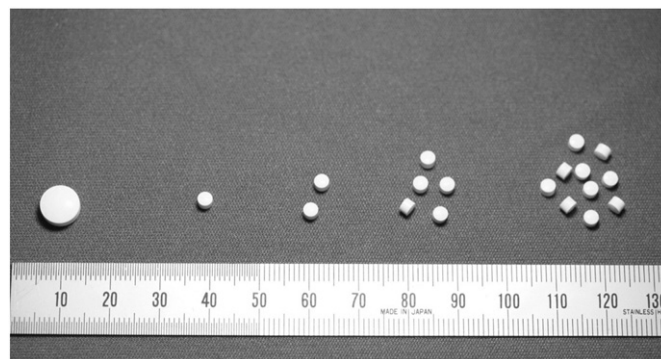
Conventional tablet and mini-tablet used in this study. The diameters of a conventional tablet (CT) and mini-tablet (MT) were 8.0 and 3.0 mm, respectively. The total weight of tablets between 1 CT and 10 MTs was equal. Volunteers took 1 CT or 1, 2, 5, and 10 MTs in the second trial. Scale is in mm.
